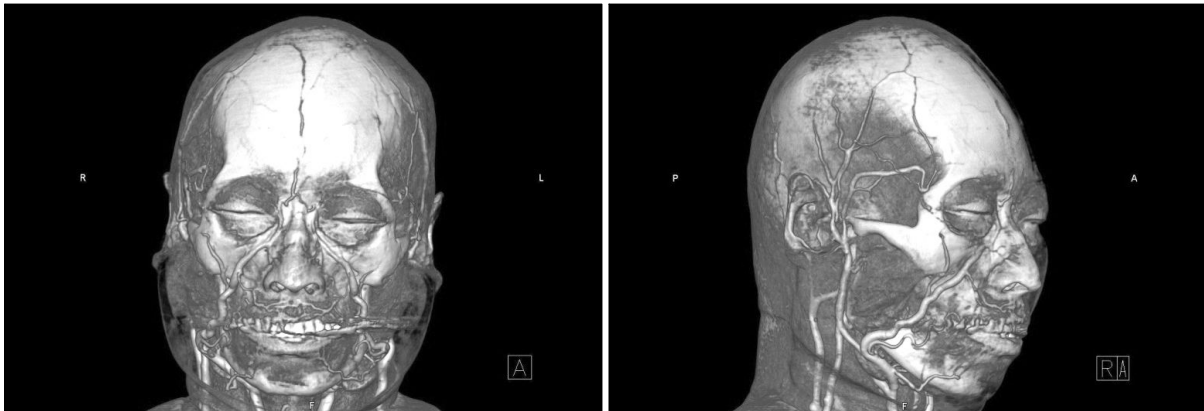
Preoperative 3D reconstruction with angio-CT scan focusing on facial artery. Angio CT shows size, location and course of facial artery with high resolution and accuracy.
